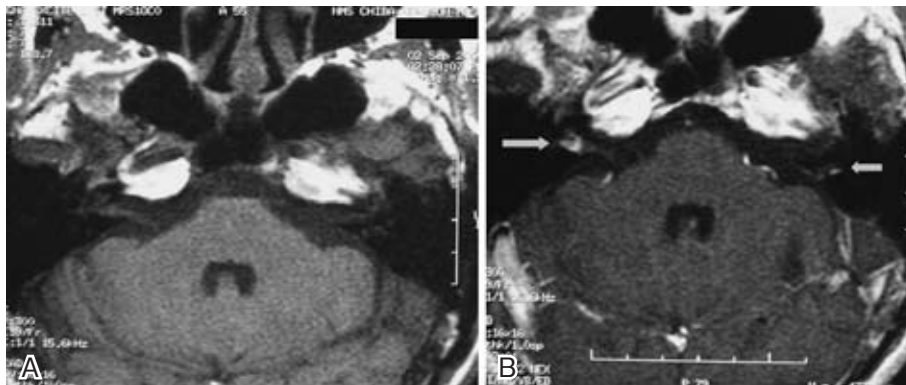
A: In simple MRI, we did not accept findings. B: In Gadolinium contrasting MRI, high signal level was accepted by both internal acoustic meatus and thought with invasion of a tumor.
